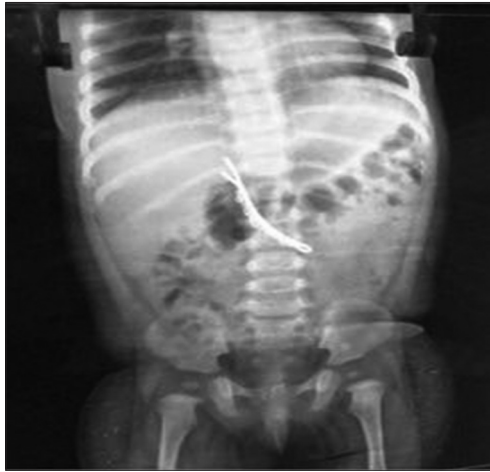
X-ray erect abdomen showing foreign body
